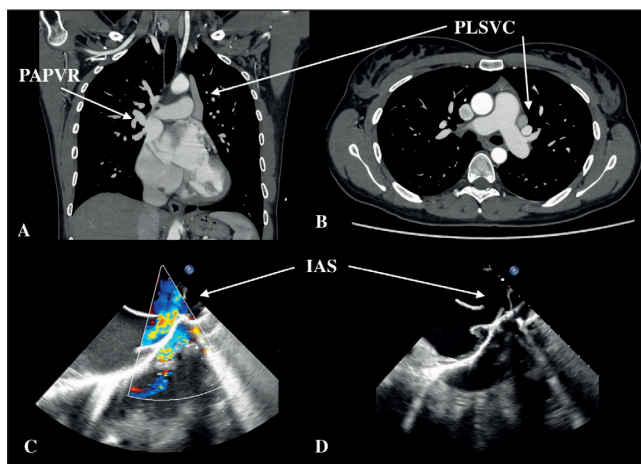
(A) Computed tomography coronal view showing the partial anomalous pulmonary venous return. (B) Computed tomography axial view showing the persistent left vena cava superior. (C, D) Transesophageal images showing the interatrial septum. IAS – interatrial septum; PAPVR – partial anomalous pulmonary venous return; PLSVC – persistent left vena cava superior.
